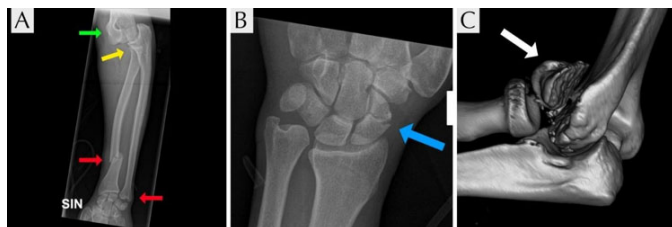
(A) Radiograph of the left forearm showing elbow dislocation (green arrow), radial head fracture (yellow arrow), and radial shaft fracture with dislocation of the distal radioulnar joint (DRUJ) (red arrows). (B) Radiograph of the left wrist showing a scaphoid fracture (blue arrow). (C) Three-dimensional (3D) computed tomography (CT) reconstruction of the left elbow showing a capitellum fracture (white arrow).
